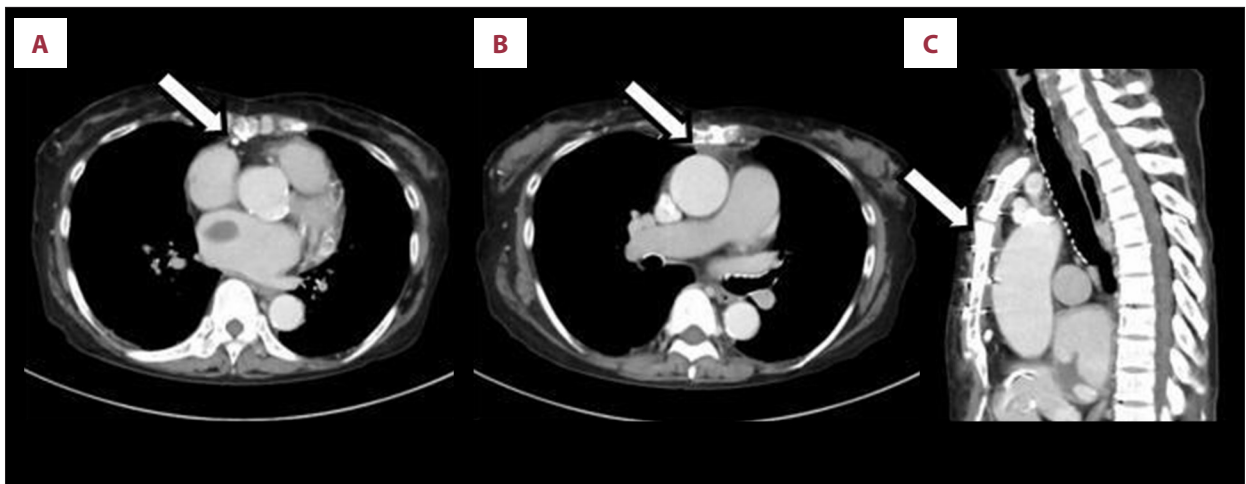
Contrast-enhanced computed tomography images. (A) Arrow indicates the right coronary artery near the back of the sternum. (B, C) High degree of collusion around the aortic root.
